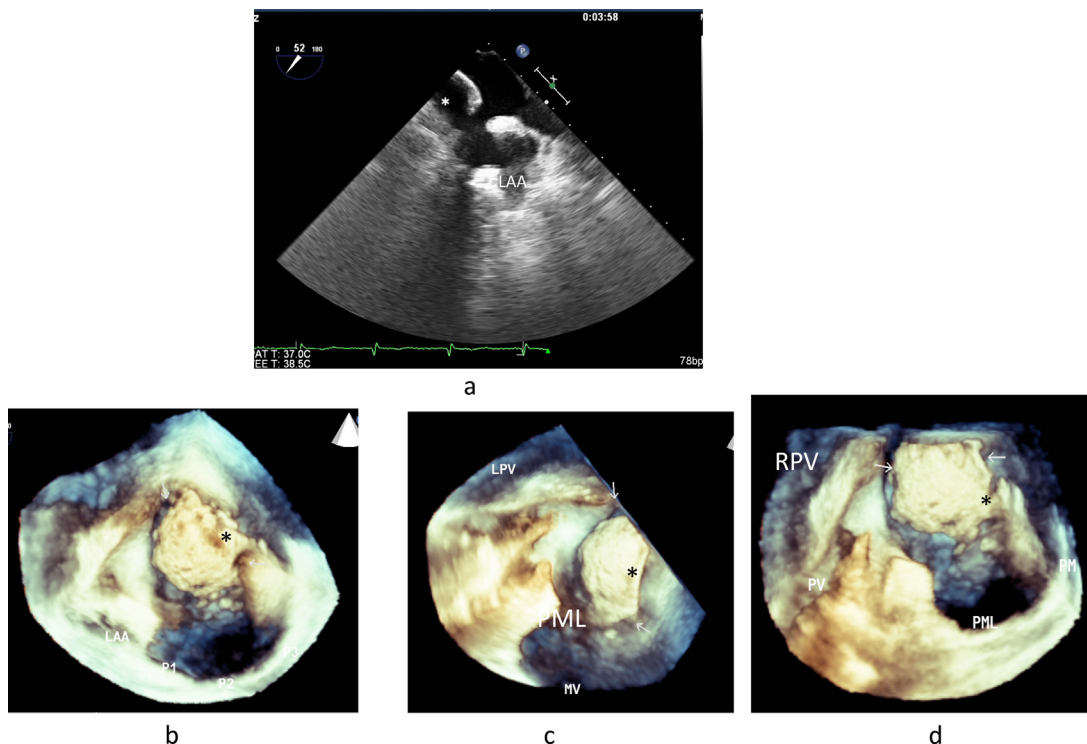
Two-dimensional (a) and three-dimensional (b–d) transesophageal echocardiography showed thrombus in the left atrium attached to the atrial septum (*). LAA, left atrial appendage; LPV, left pulmonary vein; MV, mitral valve; PML, posterior mitral leaflet; RPV, right pulmonary vein.
